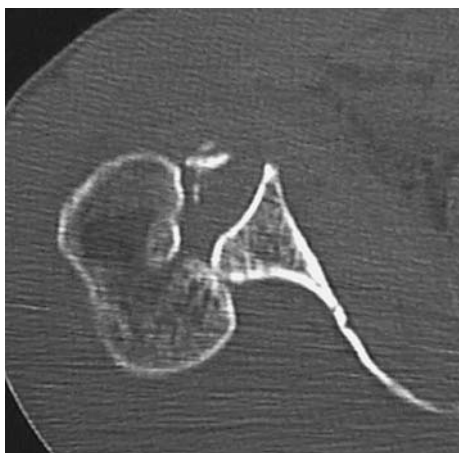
Pre-operative CT scan of a two-part fracture with articular impression fracture (case 6)
